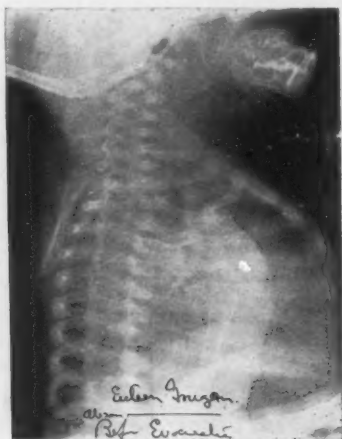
Retropharyngeal abscess in an infant, age 6 months. Glandular or tonsillar origin, four days' duration. Roentgenogram shows considerable retropharyngeal swelling, which pushes the trachea forward, angulating it.
